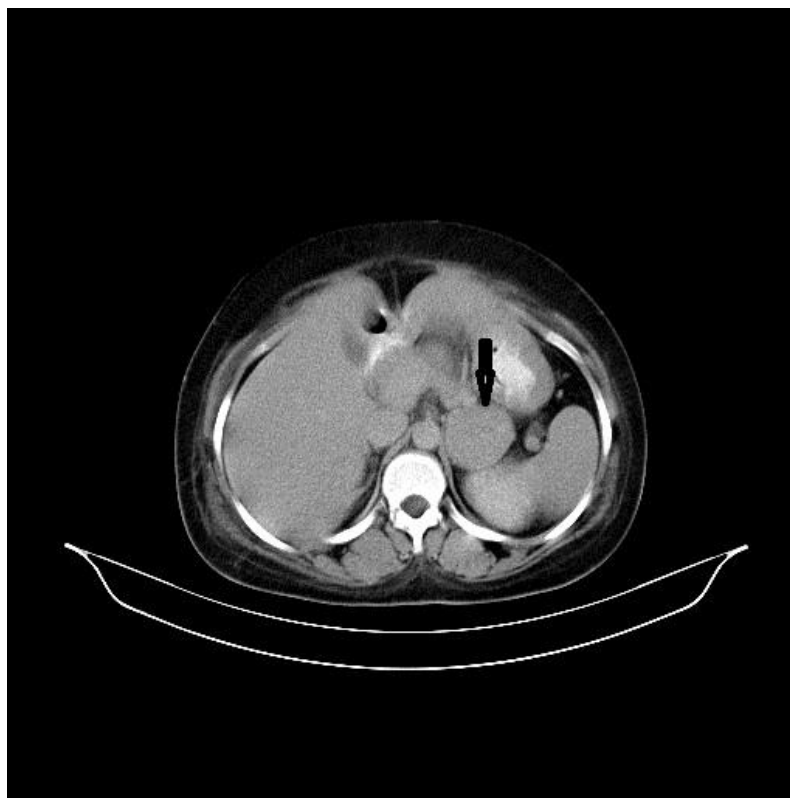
Computed tomography abdomen showing left adrenal mass (arrow)
